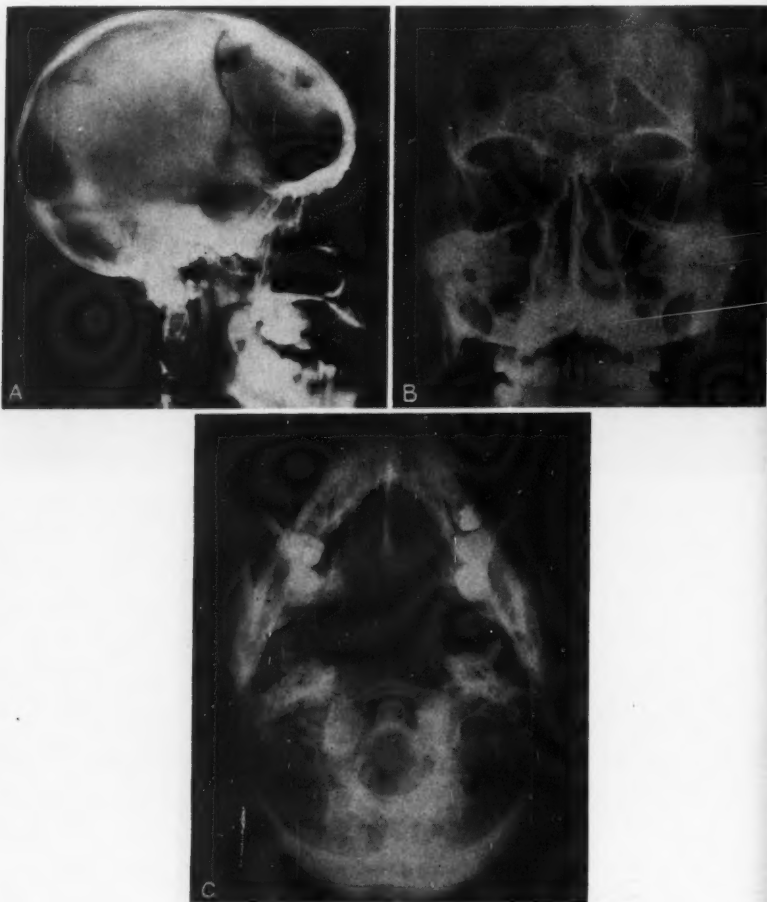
Preoperative roentgenograms in 1954.
